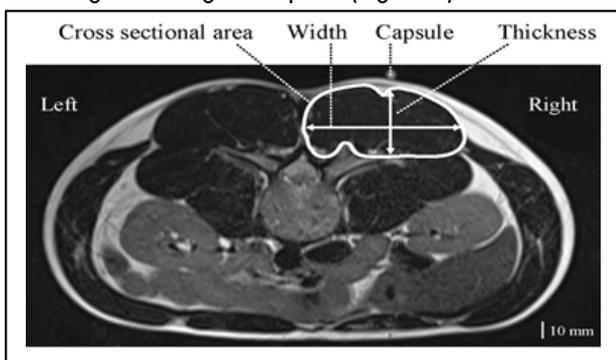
Measurement of the longissimus thickness, width and cross-sectional area of erector spinae by magnetic resonance imaging.
